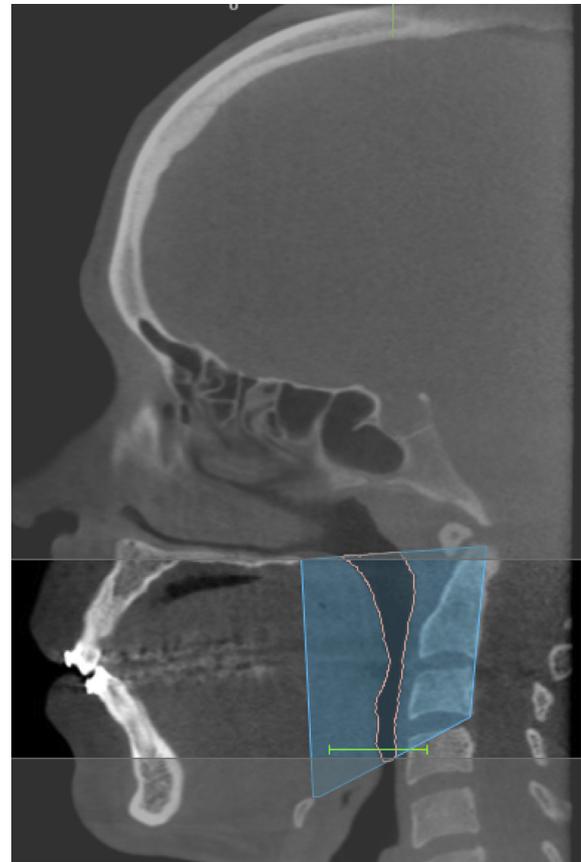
Computed tomography in a sagittal section showing the area of pharyngeal airway space (PAS) in preoperative period.
